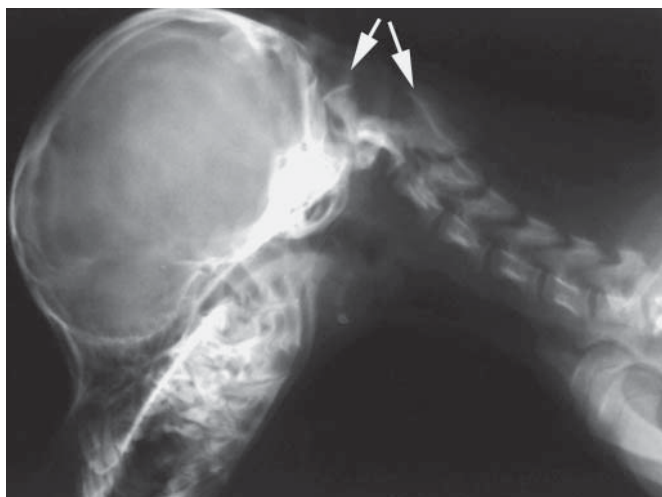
Preoperative lateral radiograph of a Yorkshire terrier with AAS. The distance between the dorsal arch of the atlas and the dorsal spine of the axis is enlarged (arrows). The cranial aspect of the body of the axis is dislocated to dorsal. Dens axis is hypoplastic.
